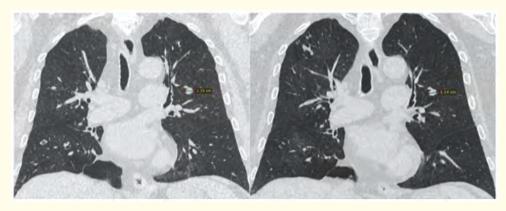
Coronal CT reformation displaying left upper lobe pulmonary nodule showing strict stability in 6 months apart control CT.
